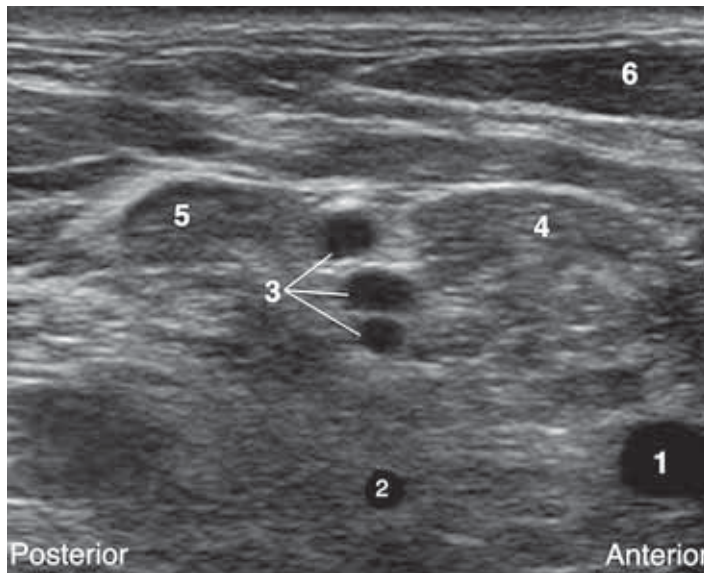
Transverse sonogram of the interscalene area: 1. Subclavian artery; 2. Vertebral artery; 3. Trunks of the brachial plexus; 4. Anterior scalene muscle; 5. Middle scalene muscle; 6. Sternocleidomastoid muscle.
